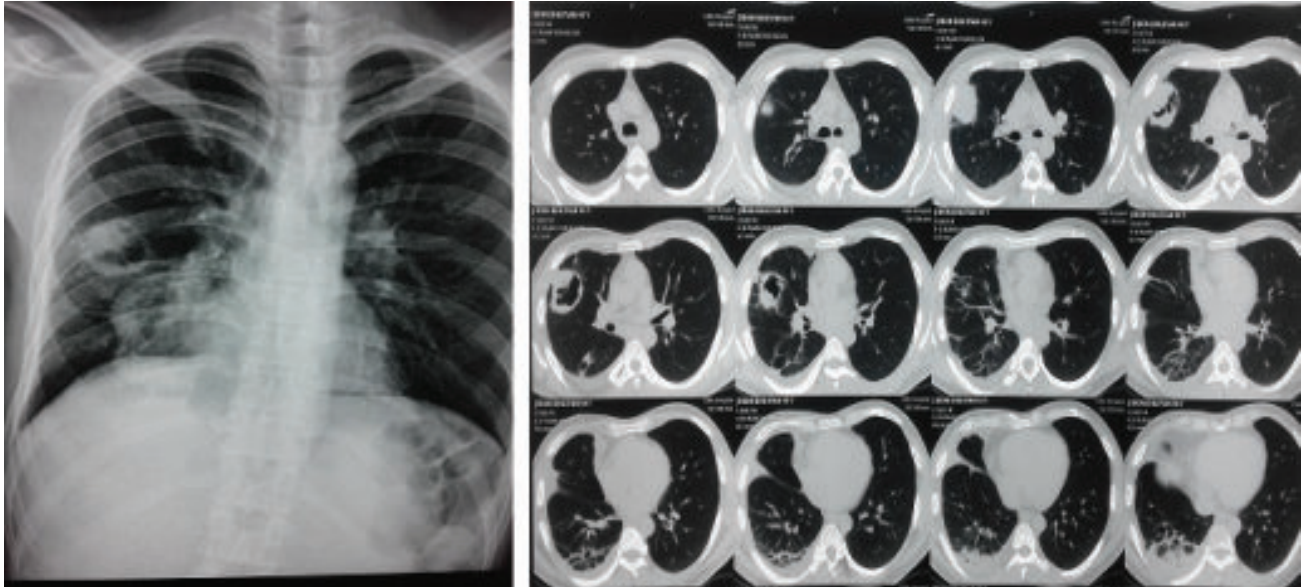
(a&b): Two cavities in right lung field and also in CT scan of chest
